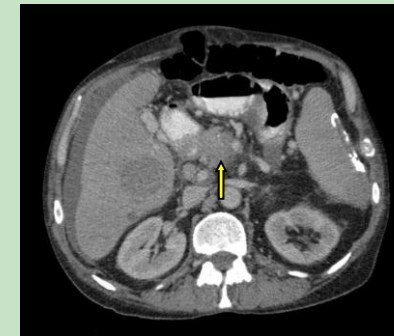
CT scan imaging of the abdomen showing pancreatic abscess (arrow).
